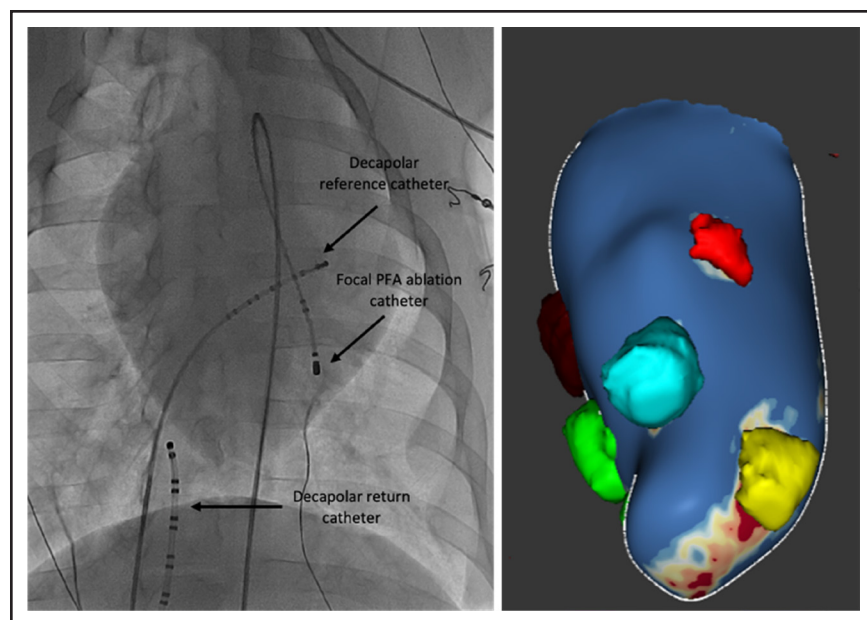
Study setup and cardiac magnetic resonance imaging (cMRI) reconstruction.
